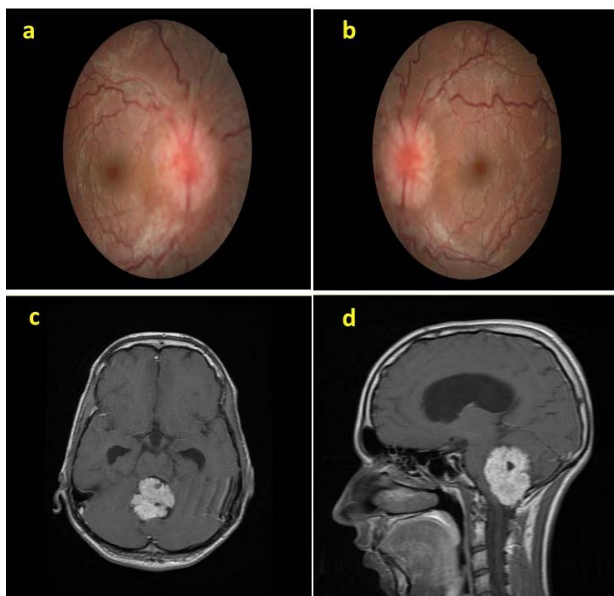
a-b. Fundoscopy showed bilateral optic disc edema (papilledema). c-d. MRI indicated a posterior fossa mass, later diagnosed as medulloblastoma
